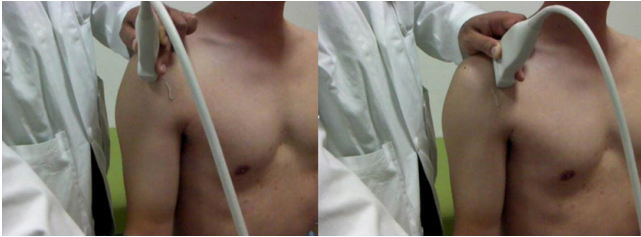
The transducer was held vertically during ultrasonography and continuously moved laterally to medially, which corresponded to a scan of the long axis of the long head of the biceps to the short axis of the subscapularis.
